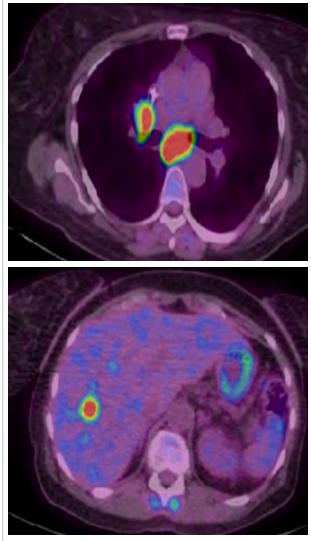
PET-CT of A, chest, right hilar soft tissue mass, SUV 9.2, plus subcarinal node (SUV 12.8), and B, abdomen, with hypermetabolic focus in liver.
